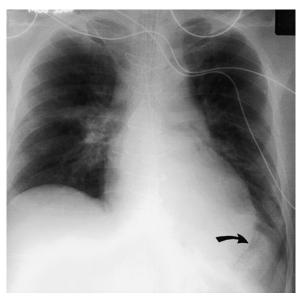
Deep Sulcus Sign. Portable supine radiograph in a patient following median sternotomy. Note the increased lucency in the left upper quadrant. The highest portion of the thorax in a supine patient is the anterior cardiophrenic sulcus; this accounts for the well-defined low cardiac border (arrows) and the adjacent fat pad.
